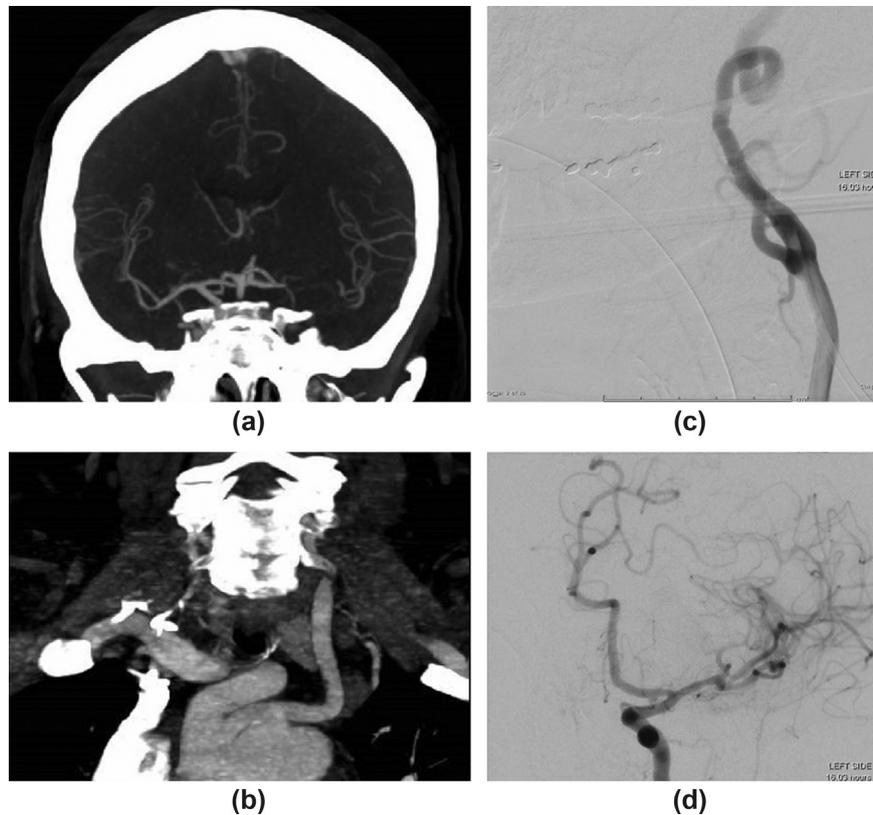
(a) Example case showing occluded left terminal ICA on coronal CTA. (b) Challenging aortic arch anatomy is also demonstrated. Direct common carotid sheath 6 F placement (c) and successful recanalisation (d).
